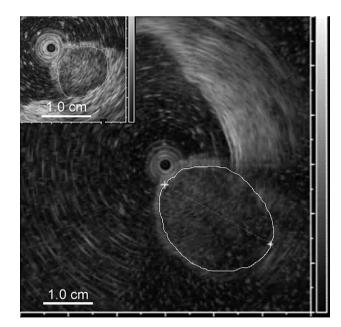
The last endoscopic ultrasound (EUS) picture of one patient during follow-up was compared to the initial EUS lesion (left upper insert) with aid of ImageJ software for both one-dimensional (1D) and 2D measurements.
